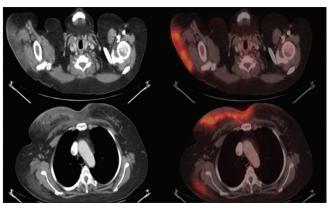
Axial images of positron emission tomography-computed tomography showing areas of skin and subcutaneous thickening and fluorodeoxyglucose uptake
